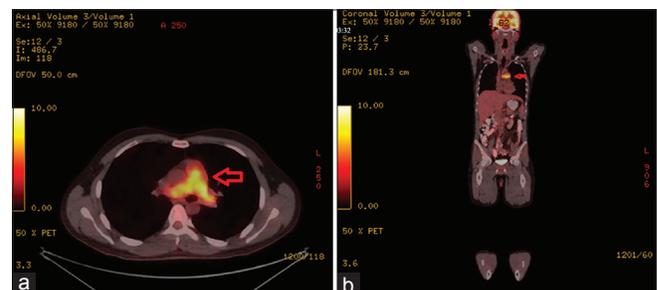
(a and b) A PET-computed tomography scan shows pathological F-fluorodeoxyglucose uptake in the same area (red arrow) after failed the pulmonary thromboendarterectomy therapy. PET: Positron emission tomography
